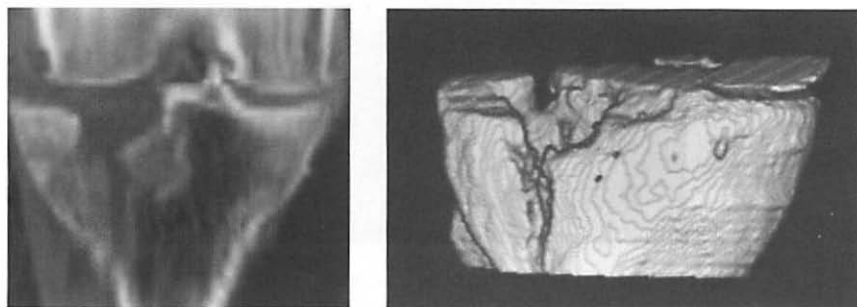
a,b: LATERAL PLATEAU FRACTURE: Coronal CT reconstruction (a) and 3-D image (b), showing relationship of plateau depression to fragment lines. Note removal of condyles except for small fragment medially.
